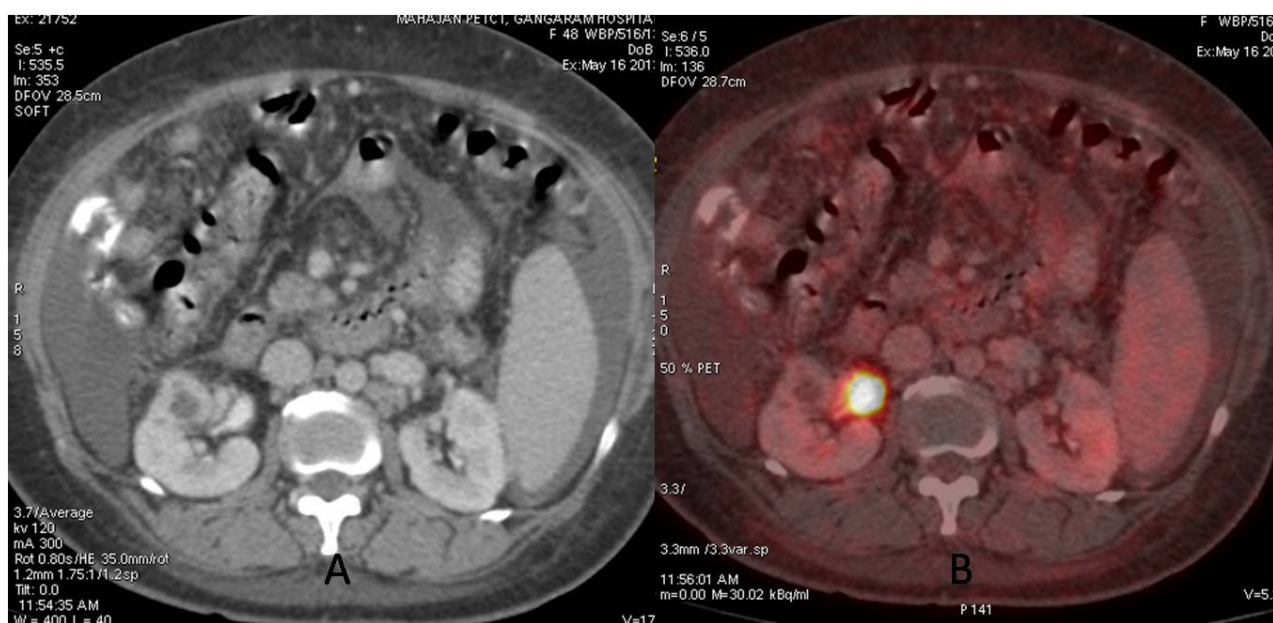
CT showing a heterogeneously enhancing cystic lesion (Bosniak type III/IV) in right kidney (A) which was not FDG avid on FDG PETCT (B)
